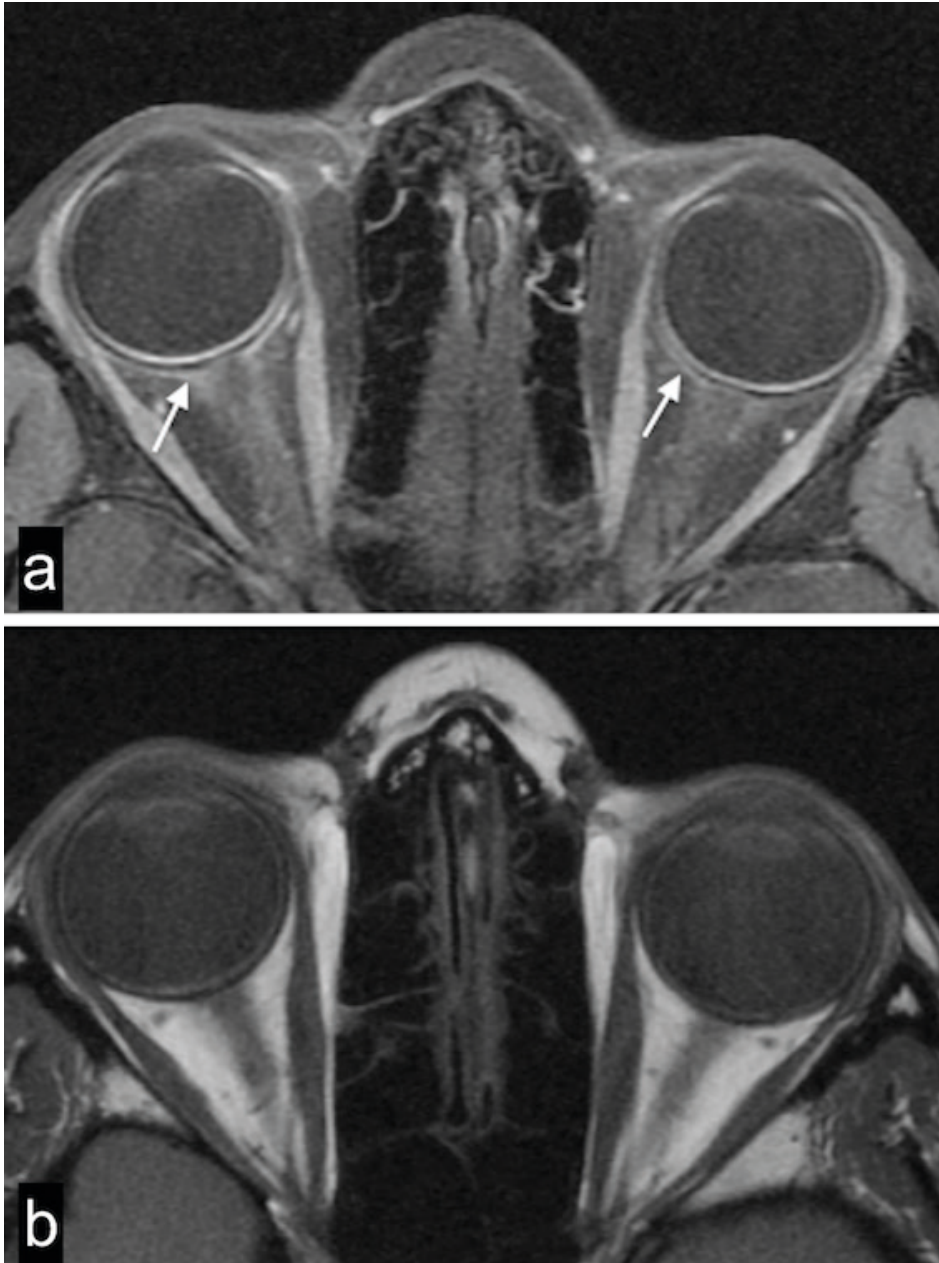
Bilateral inflammatory isolated scleritis. axial MRI images.
